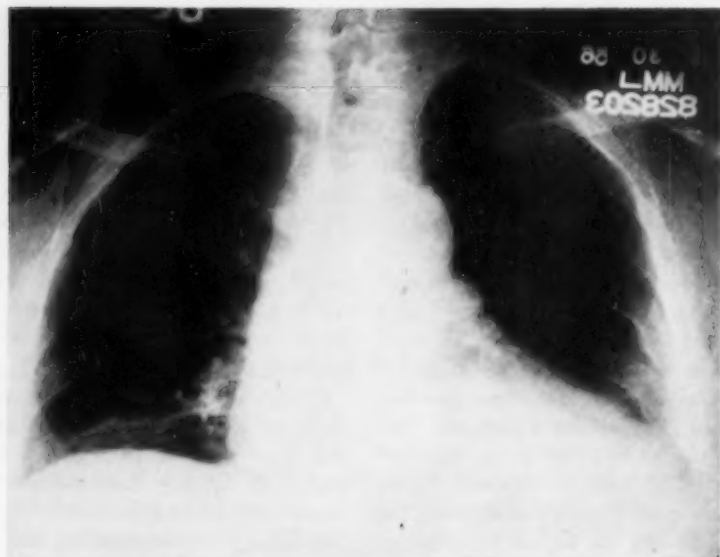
Radiograph of the chest showing elevation of both hemidiaphragms and "blunting" of the costophrenic sulci.
